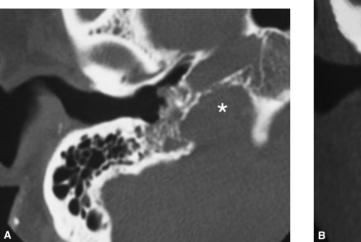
Jugular foramen paraganglioma. Axial (A) and coronal (B) CT scan demonstrating a large jugular foramen tumor with extension into the middle ear, mastoid, and the neck (B). There is expansion of the jugular bulb region (*).
